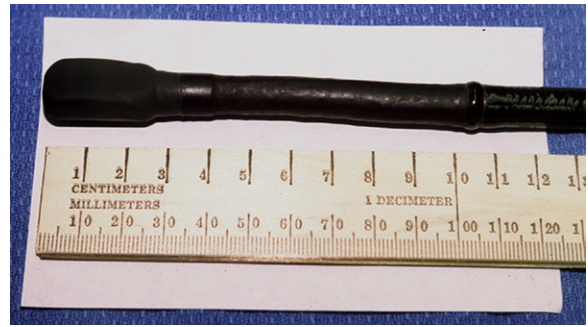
Transesophageal echocardiography probe. Distal tip contains thermistor and piezoelectric elements.
